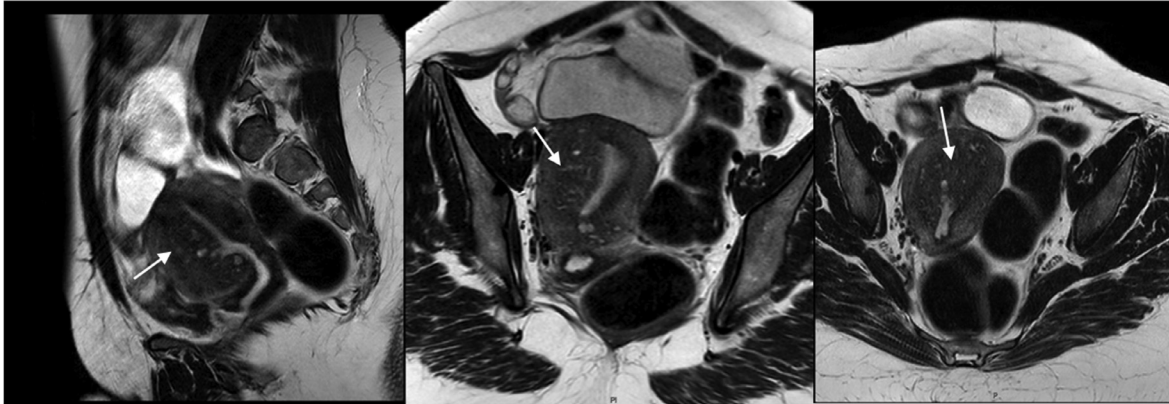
MRI images showing type I adenomyosis (white arrow).
